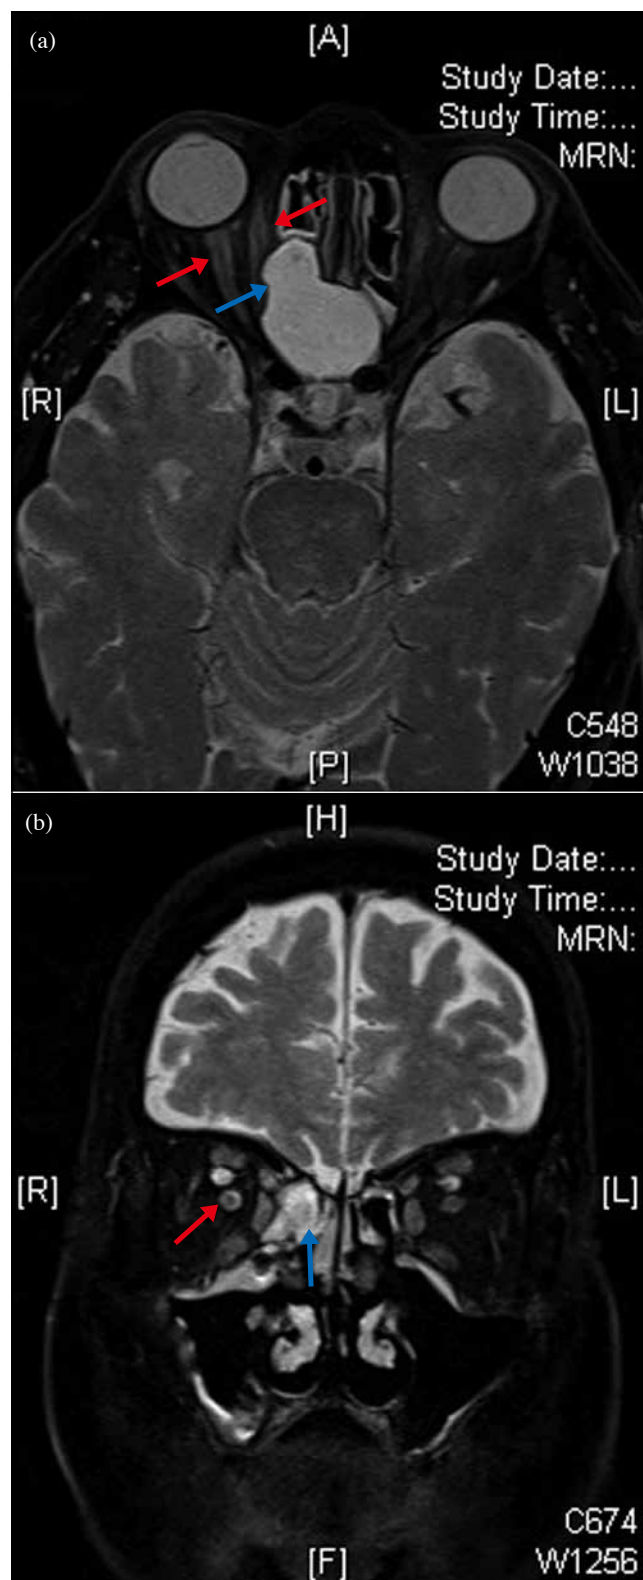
An 80-year-old male having right optic perineuritis after an episode of upper respiratory tract infection, with visual acuity down to light perception: T2 magnetic resonance imaging of the optic nerve demonstrates the (a) tram track sign (red arrows) and (b) donut sign (red arrow). There is a coincidental finding of mucocoele in the ethmoid sinus (blue arrows).
